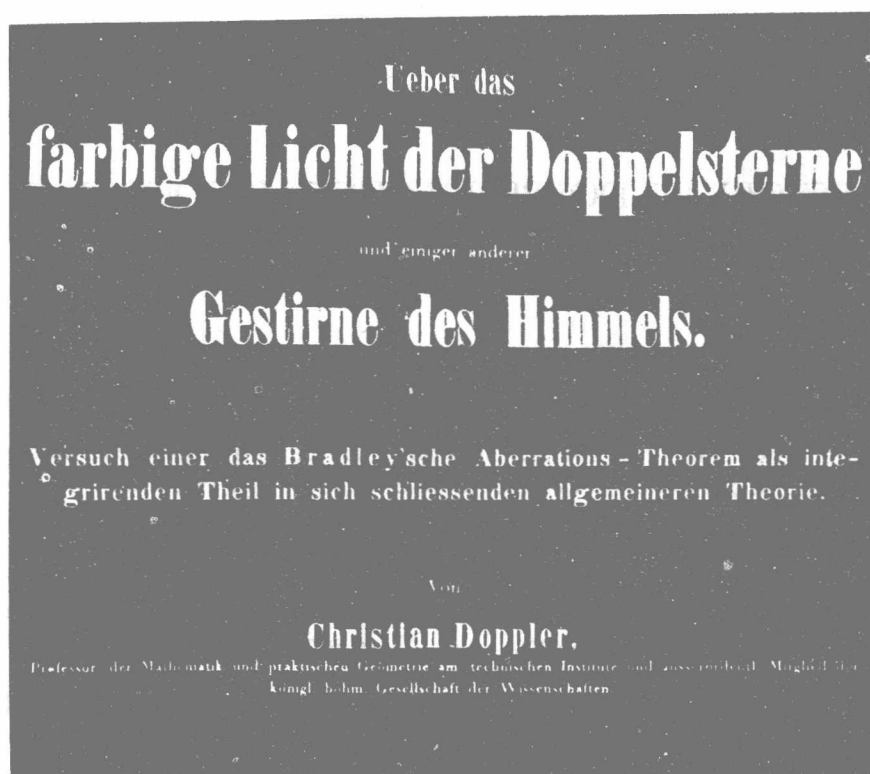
Photographic reproduction of the cover page of Dr. Doppler's article published in 1842.
